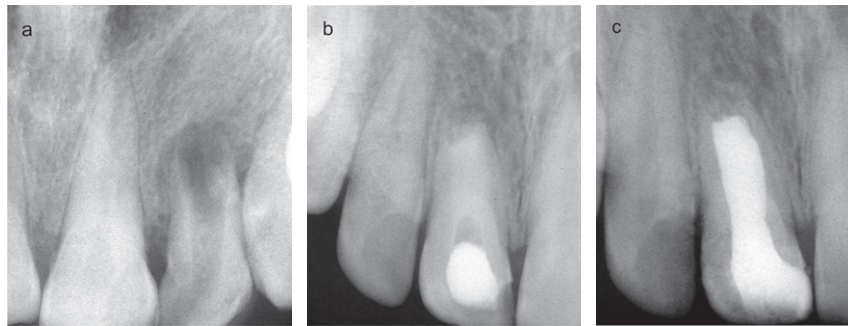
(a) Pre-operative radiograph reveals an immature root with an open apex in the left maxillary central incisor. (b) After placement of calcium hydroxide for several months, an apical barrier developed. (c) The canal was filled with gutta-percha and sealer using a lateral condensation technique.
